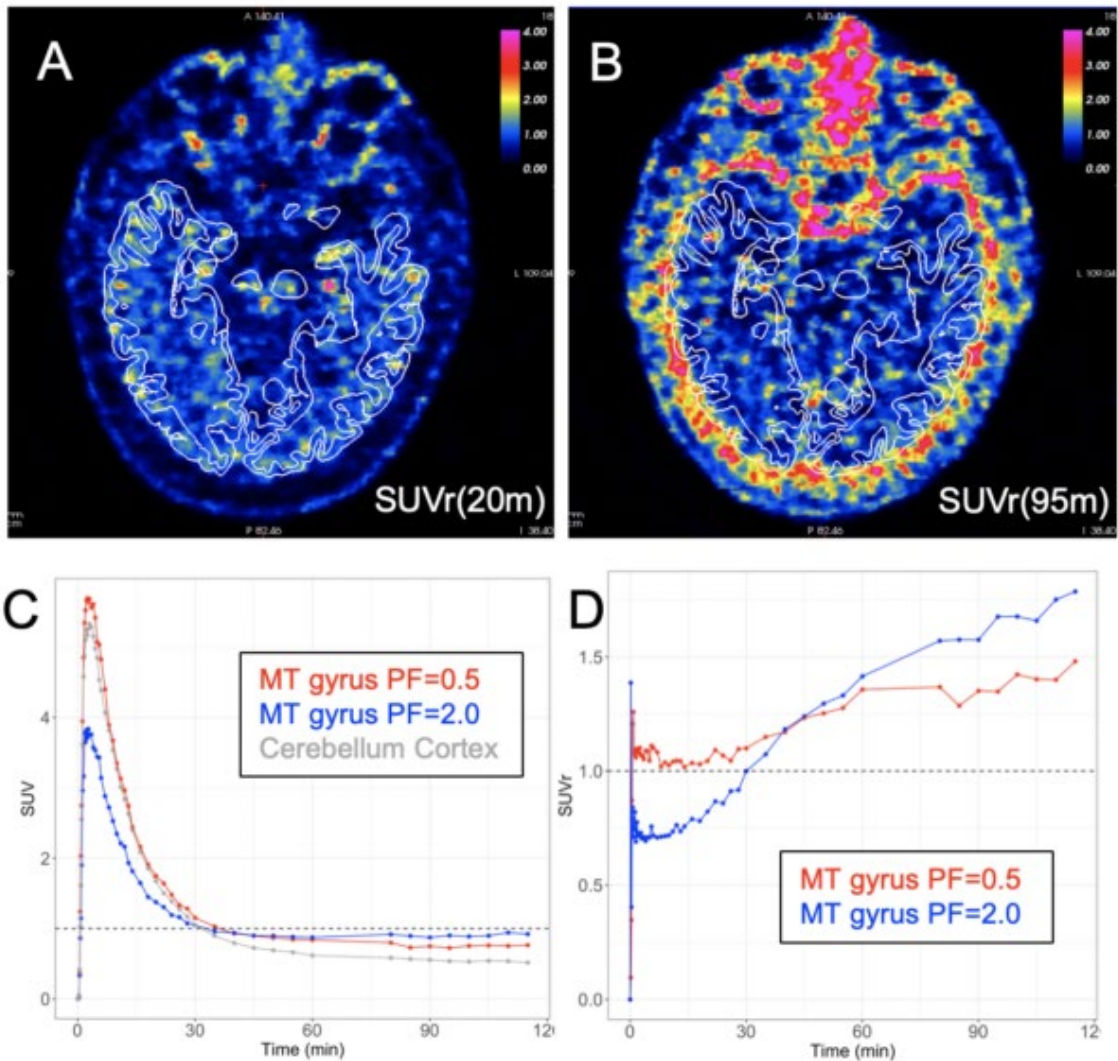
Cognitively normal 75 year-old female with low amyloid (PiB FLR=1.11) *Top*, axial view of MK-6240 SUVr at 20min (A, left) and 95min (B, right) post-injection; white lines indicate FreeSurfer-defined white and pial surface boundaries. *Bottom*, time activity curves for MK-6240 SUV (C) in middle temporal (MT) gyrus at PF=0.5 (red) and PF=2.0 (blue) in relation to cerebellum cortex (grey), MT SUVr normalized to cerebellum cortex (D).
